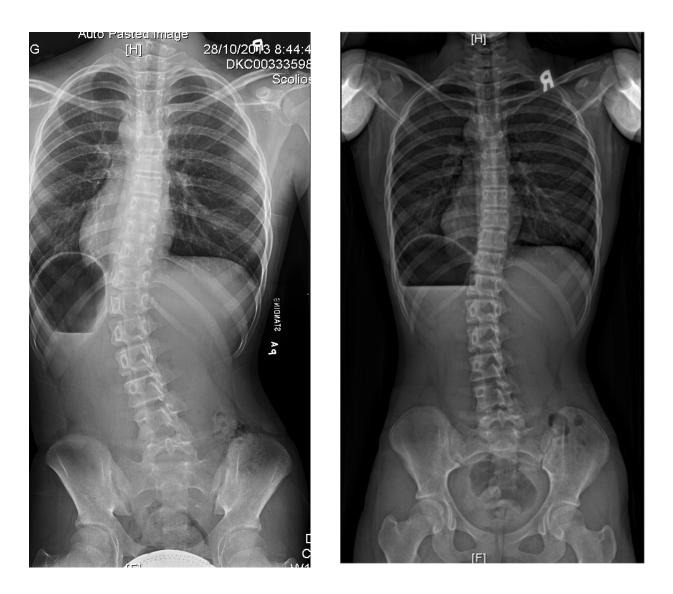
These radiographs are of a patient with improved curve magnitude, with (A) a prebrace standing radiograph showing a T10-L3 curve of 30° and (B) a post-brace standing radiograph showing curve regression of 15°.
